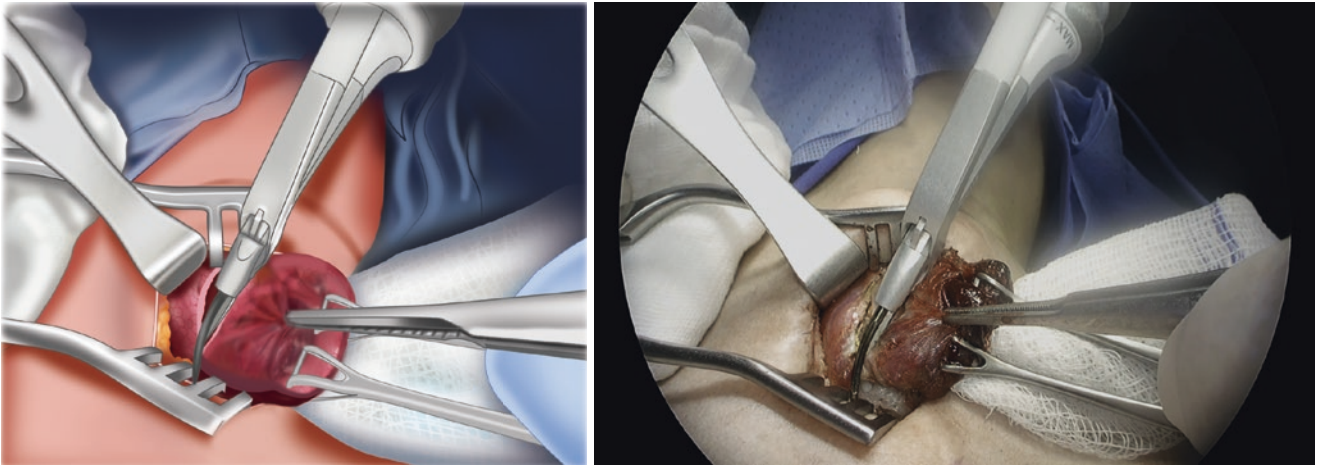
Thyroid isthmus transection. The thyroid isthmus is transected using an ultrasonic energy device
